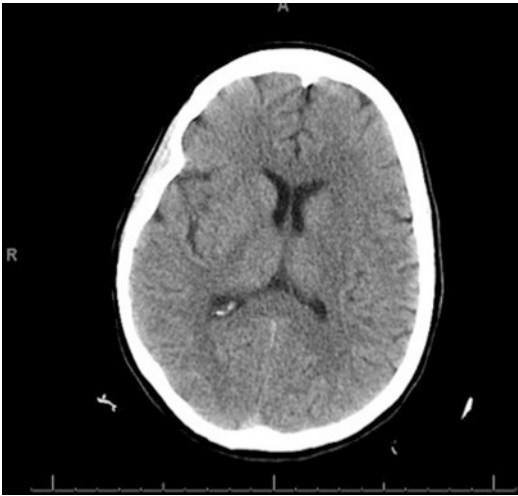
Non-contrast head CT at initial presentation. There was no evidence of cerebral edema despite markedly impaired mental status
